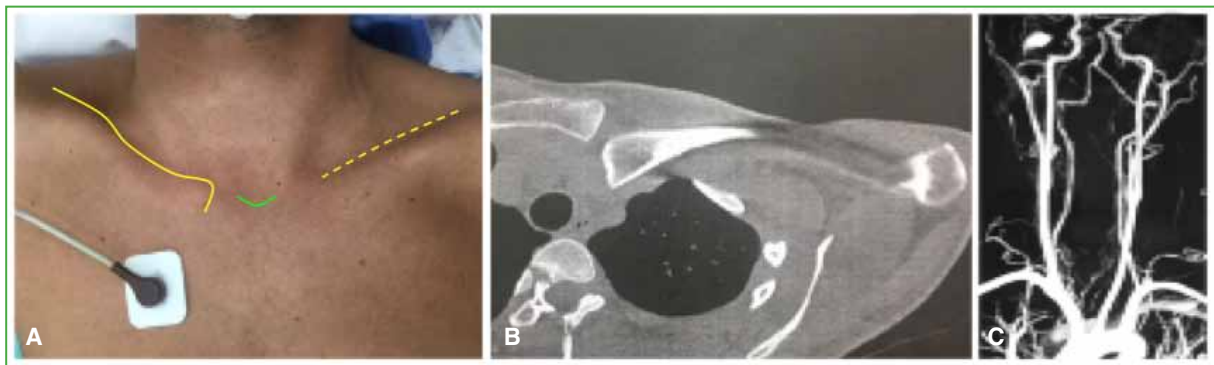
A. Normal silhouette of the right clavicle (solid yellow line) with depression of the medial epiphysis of the left clavicle at the sternoclavicular joint (dashed yellow line). The central green line highlights the contour of the sternal manubrium. B. CT of the sternoclavicular joint, axial view, showing posterior sternoclavicular dislocation with mediastinal displacement of the medial clavicular epiphysis. C. Neck MR angiography, normal.
